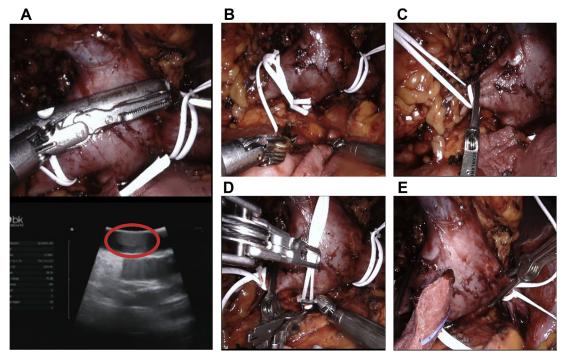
Robotic approach to level II thrombi. Intraoperative ultrasound examination enables to define the limits of the thrombus (*red circle*), which in this case is extending outside the ostium of the right renal vein (*A*). Mobilization and control with a double-loop vessel loop secured by a Hem-o-Lok clip of the infrarenal and suprarenal IVC, as well as the left renal vein is paramount (*B*). We use bulldog clamps to clench the vessels. This is aided by the tightening of the tourniquet. The infrarenal IVC should be the first segment to be interrupted (*C*). These steps are repeated to close the circulation of the left renal vein (*D*) and suprarenal IVC (*E*), in that order.
